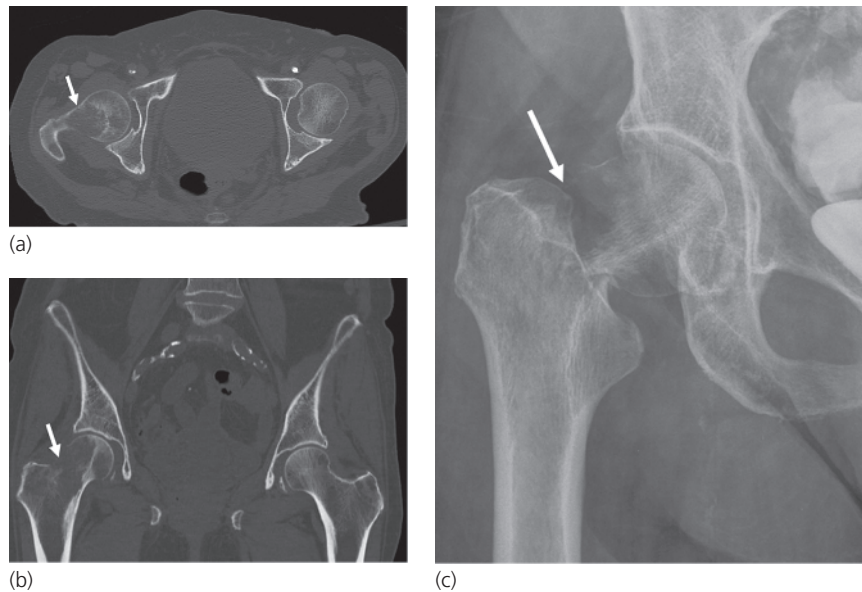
CT for assessment of pathologic fracture risk. (a) Axial and (b) coronal reformatted images show a large lytic lesion in the right femoral head and neck (arrow) with cortical destruction laterally and posteriorly. (c) Two weeks later, radiograph shows a displaced subcapital pathologic fracture (arrow) impacted in varus.
